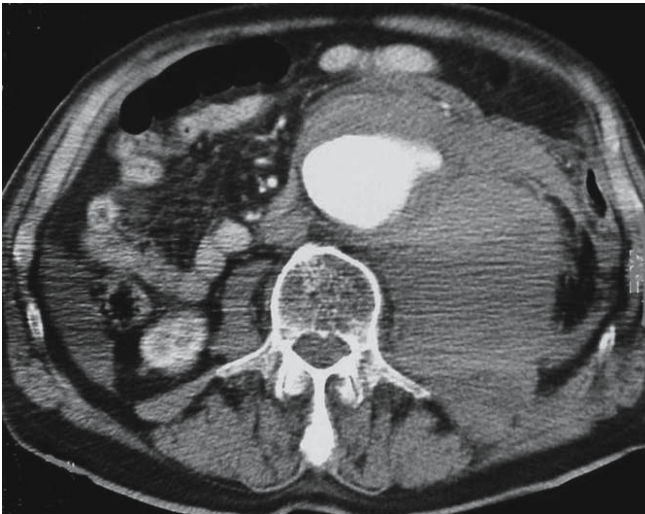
Abdominal CT: leaking abdominal aortic aneurysm. See the aortic aneurysm and large retroperitoneal hematoma on the left
